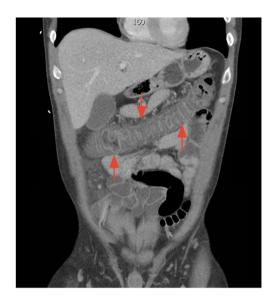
Coronal section of abdominal CT scan of the man (first patient's partner), with arrows demonstrating colonic mucosal thickening with fat stranding at the transverse colon, consistent with colitis.
